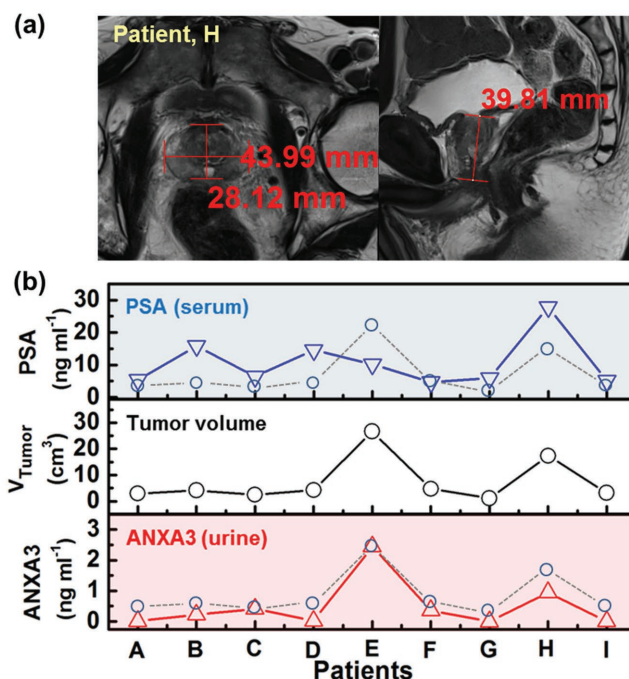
a) Cross sectional and longitudinal MRI images of a prostate cancer. b) PSA levels in serum, real tumor volumes, and ANXA3 levels in urine for the selected prostate cancer patients.
